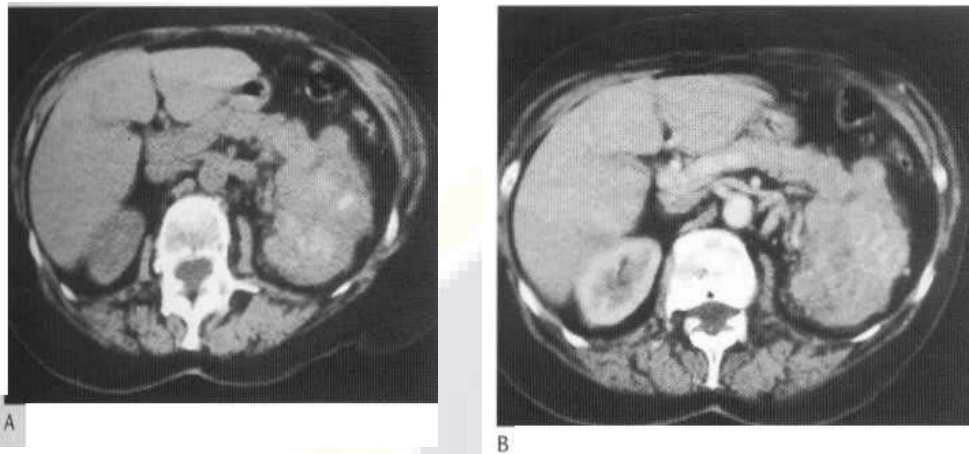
Stage IV tumours. Left renal cell carcinoma with areas of calcification seen on the unenhanced CT (A). The tumour has invaded into the tail of the pancreas (B). Right renal cell carcinoma invading the psoas muscle, anterior abdominal wall and adjacent bowel (C).
